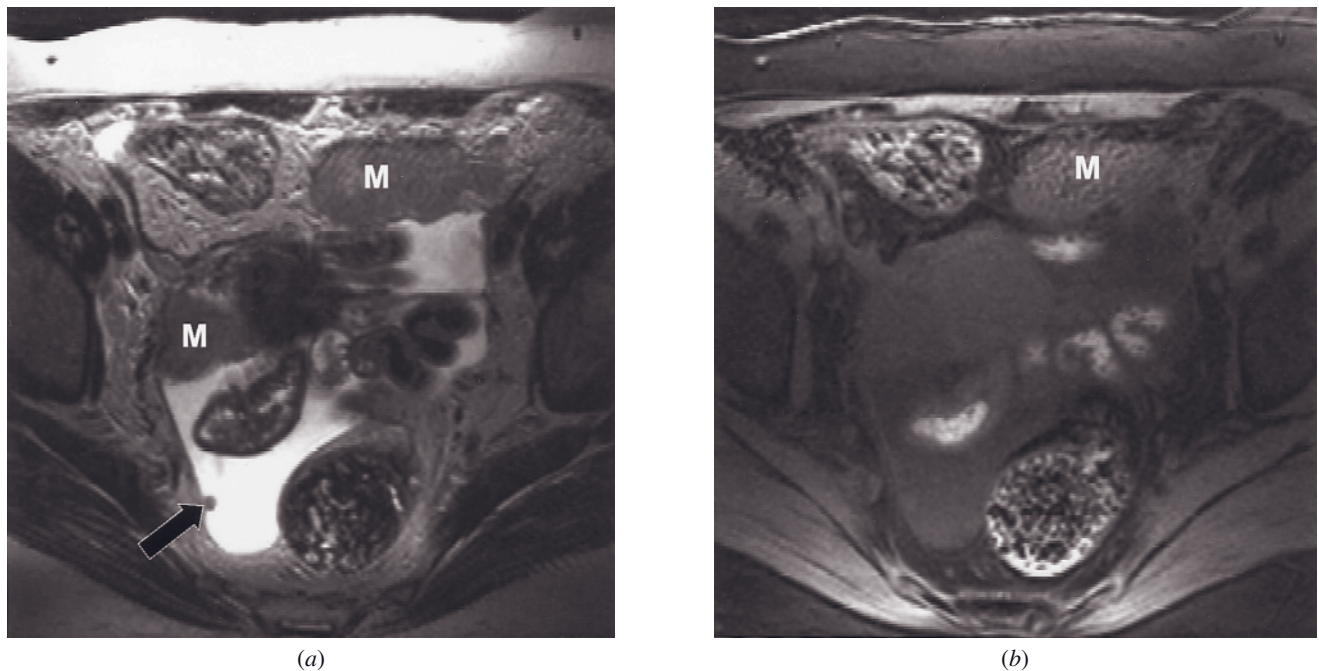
Peritoneal metastases. T2-weighted ETSE (*a*), T1-weighted fat-suppressed (*b*), and gadolinium-enhanced T1-weighted fat-suppressed (*c*) SE images in a 69-year-old woman with advanced ovarian carcinoma, stage III. The peritoneum is diffusely thickened and has superimposed nodules. Peritoneal metastases (arrow, *a*) are most conspicuous on T2-weighted images in the setting of ascites and after gadolinium administration on T1-weighted fat-suppressed images (arrows, *c*). Note the larger metastatic masses distributed in the pelvis (M, *a-c*). Contrast-enhanced T1-weighted fat-suppressed technique increases staging accuracy of ovarian carcinomas.
